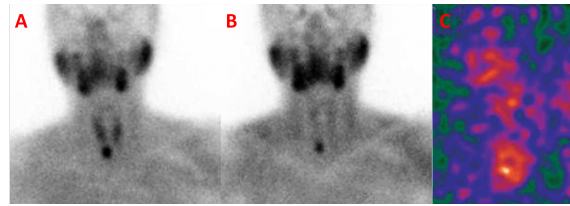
Example of a parathyroidectomy guided with an intra-operative gamma camera. (A) shows the preoperative scintigraphy during the early phase of MIBI. In (B) the parathyroid adenoma becomes clearly visible. (C) intra-operatively the adenoma can be visualized as hot spot below the thyroid [95]. Figure reproduced with permission from Elsevier.
